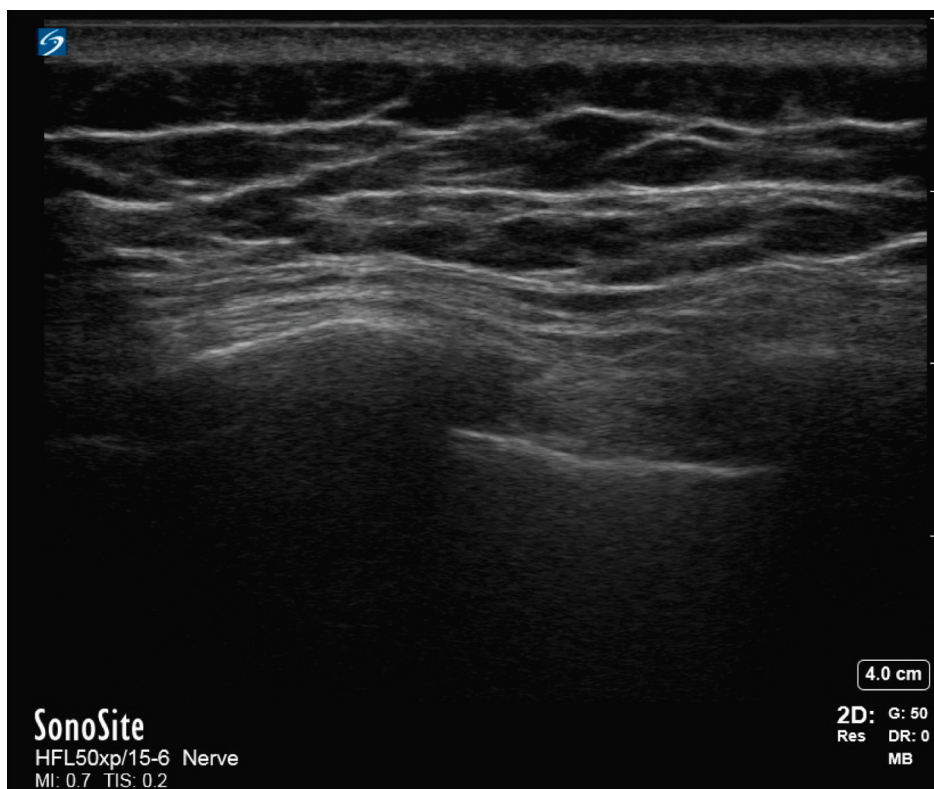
Ultrasound image of sternal fracture. Fracture sonography demonstrating a mid-body sternal fracture. The orientation indicator is cranial. The fracture site appears as a contour defect in the cortical bone of the sternal body. The upper body of the sternum is displaced posteriorly.
